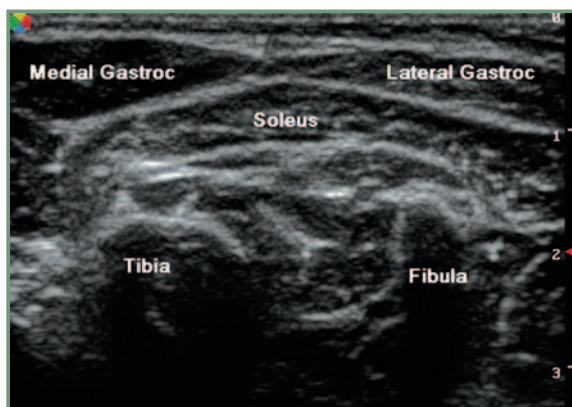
Ultrasound imaging of the gastrosoleus in a 4 year old diplegic boy.
